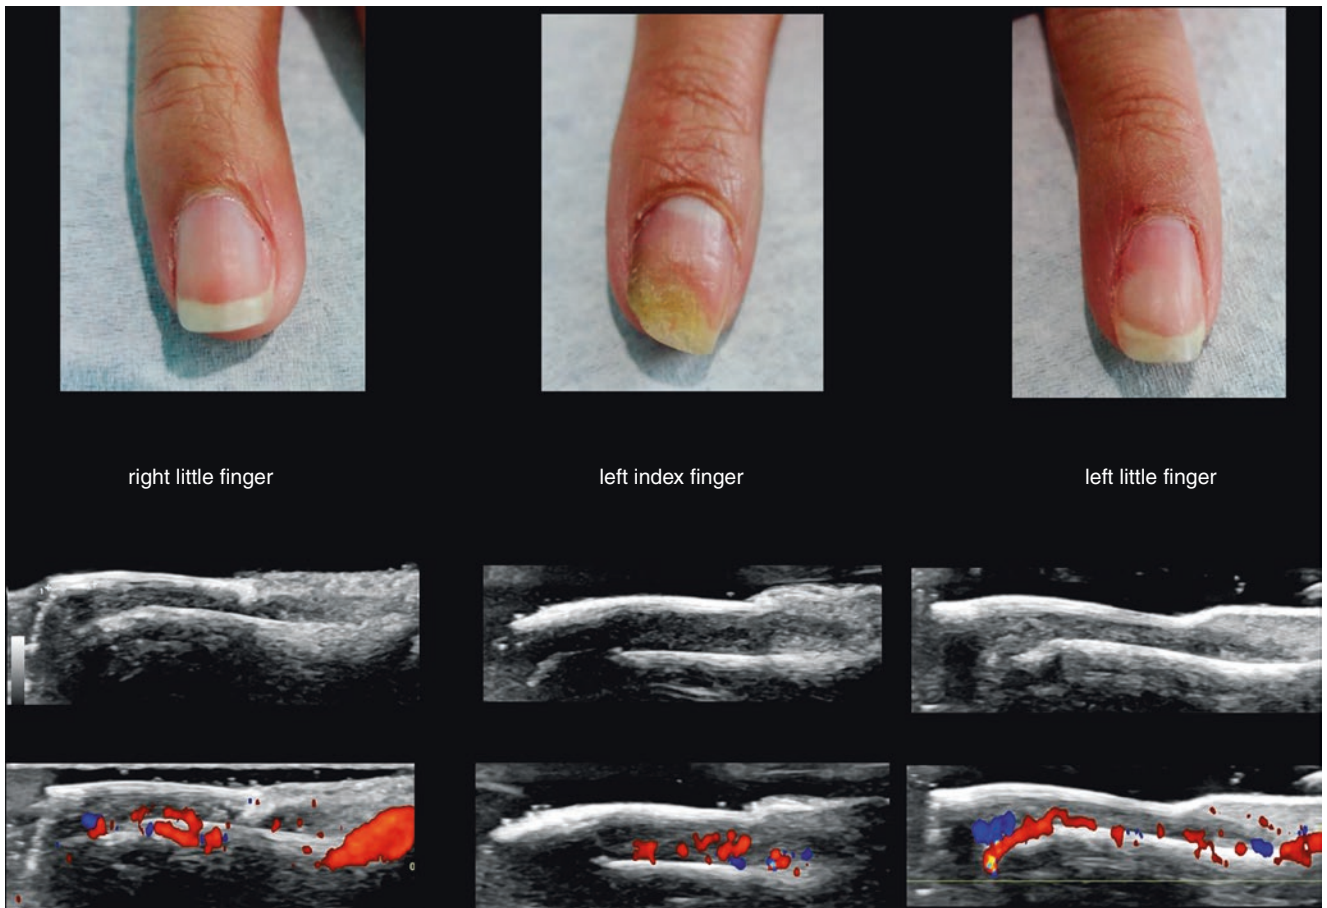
Clinical and ultrasonographic correlation in active nail psoriasis. On top, the clinical images, and at the bottom, the greyscale and color Doppler ultrasound of the same fingers. Notice the presence of variable degrees of psoriasis severity in the different fingers.
